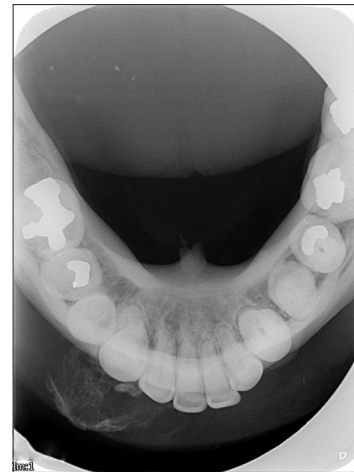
The mixed radiopacity lesion rising from the buccal aspect of the right parasymphiseal region is evident on this mandibular true occlusal radiograph, with an ill-defined periphery
